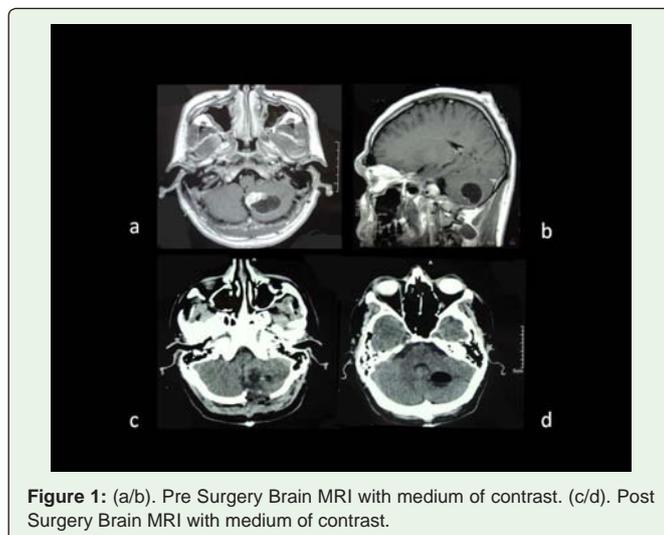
(a/b). Pre Surgery Brain MRI with medium of contrast. (c/d). Post Surgery Brain MRI with medium of contrast.
